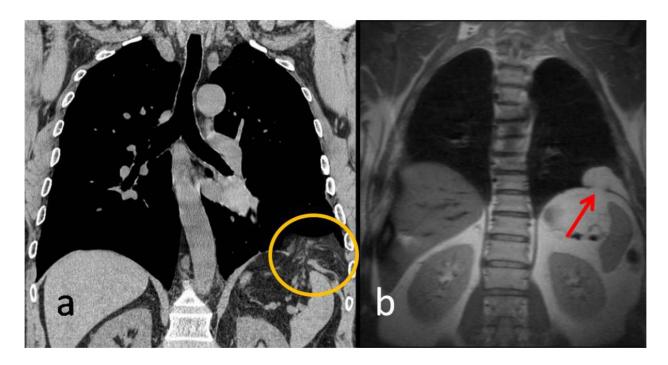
Bochdalek hernia. Coronal MIP image from CT scan (a) and coronal HASTE sequence (b) show a posterior diaphragmatic defect and herniation of omental fat and vessels.
